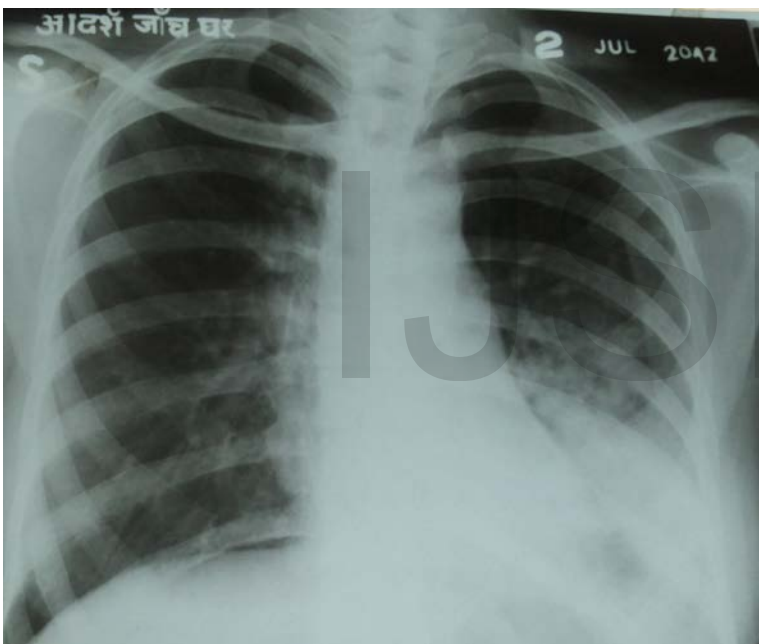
Chest x-ray at 24 months showing radiological improvement
